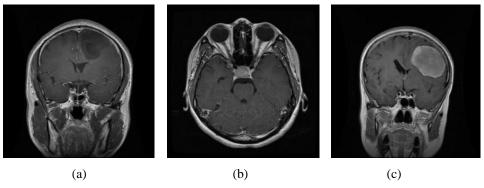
Representative MRI Images from the Figshare Dataset: (a) Glioma, (b) Pituitary, and (c) Meningioma Tumor
